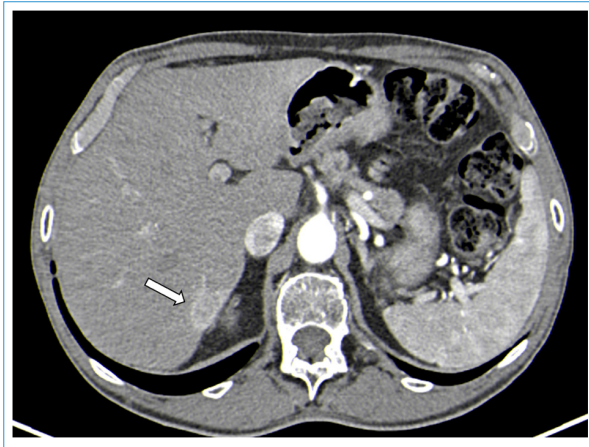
Computed tomography scan, axial arterial phase. The white arrow shows a hypervascular nodule in the VII segment measuring 19 mm.
